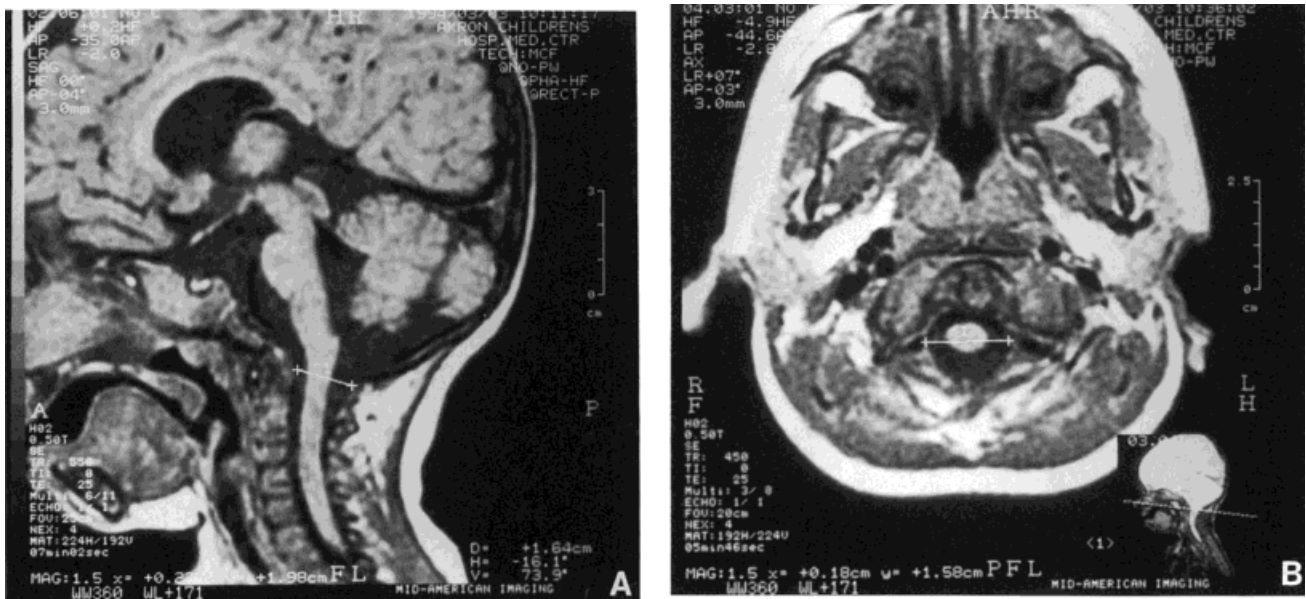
Same patient as Figure 1. A, B: MRI of the brain stem and cervical spine with measurements of both anterior-posterior and lateral dimensions of the foramen magnum. There is no evidence of cervical cord compression.
